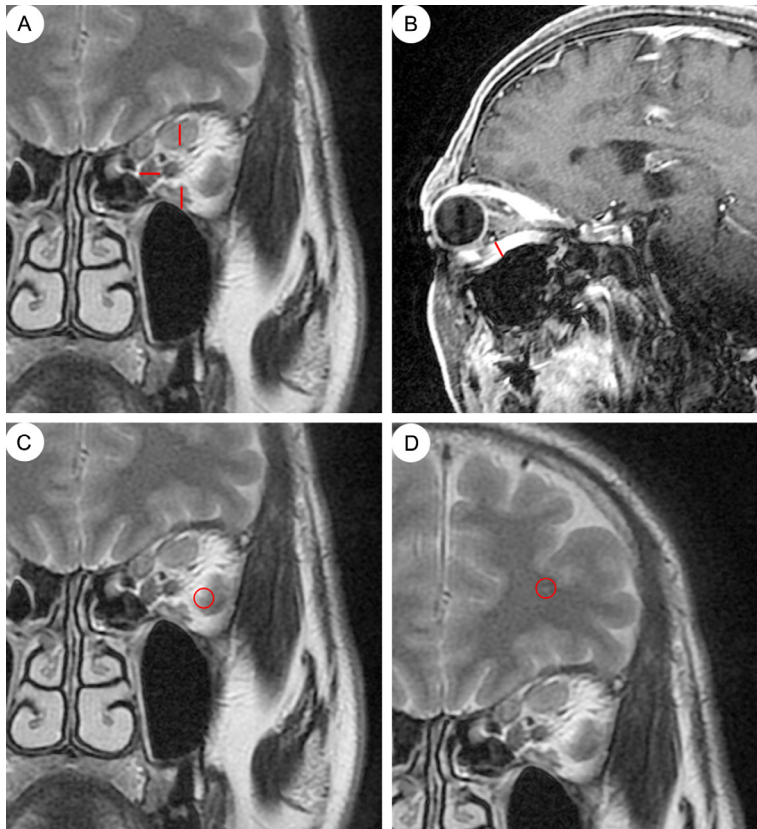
MRI imaging findings in a 52-year-old female patient with thyroid-associated ophthalmopathy (TAO) and diplopia. A: Measurement of the maximal thickness of the superior rectus, inferior rectus, and medial rectus muscles (red line segment) on coronal T2WI-FS sequence; B: Measurement of the maximal thickness of lateral rectus muscle (red line segment) on axial T2WI-FS sequence; C: Measurement of region of interest (ROI) at the area of highest signal intensity within the extraocular muscle belly (red circle) on coronal T2WI-FS sequence; D: Placement of the ROI at the area of strongest signal intensity within the ipsilateral cerebral white matter (red circle) on the coronal T2WI-FS sequence.
